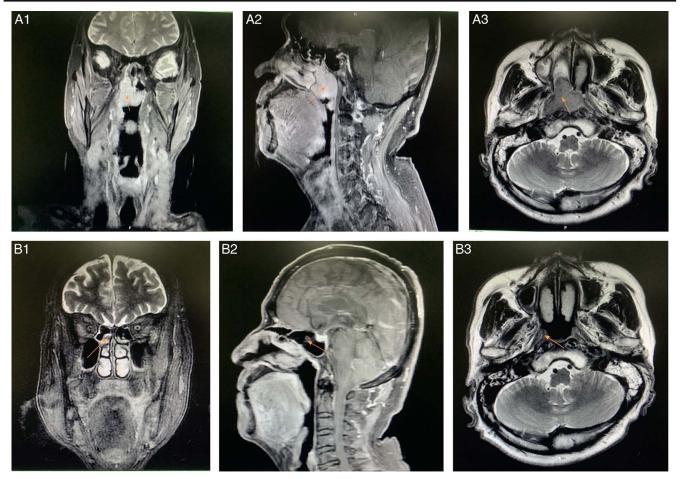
Dynamic changes in MRI of the nasopharynx during treatment: (A1/A2/A3) before immunotherapy (2020-02-15, 3.2 × 3.1 × 3.7 cm) and (B1/B2/B3) after four immunotherapy treatments [2020-05-10, 0.6 × 0.8 × 2.0 cm, indicating partial response (PR)].
